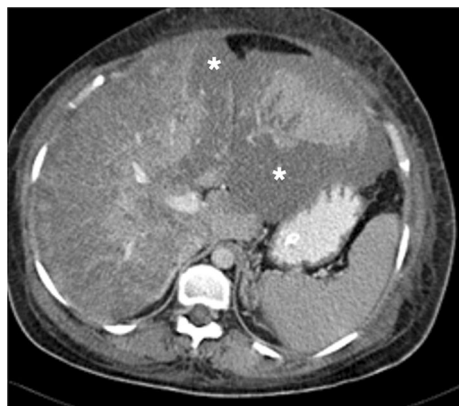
A 37-year-old female patient with 34 weeks of pregnancy presented with malaise, severe right upper quadrant pain, lethargy, significantly elevated LFTs, thrombocytopenia, and hemolytic anemia. The clinical and laboratory findings highly suggested HELLP syndrome, and an emergency cesarean section (C/S) was performed. The patient's lethargy and abdominal pain progressed, and emergent abdominal and cranial CT scans were performed 2 days after the delivery. Axial plane postcontrast abdominal CT image showed extensive liver infarction as hypodense areas with geographic distribution (asterisks). Her head CT was within normal limits (not shown). The patient responded well to ICU care and was discharged without apparent clinical sequelae 1 month after the CT scan
